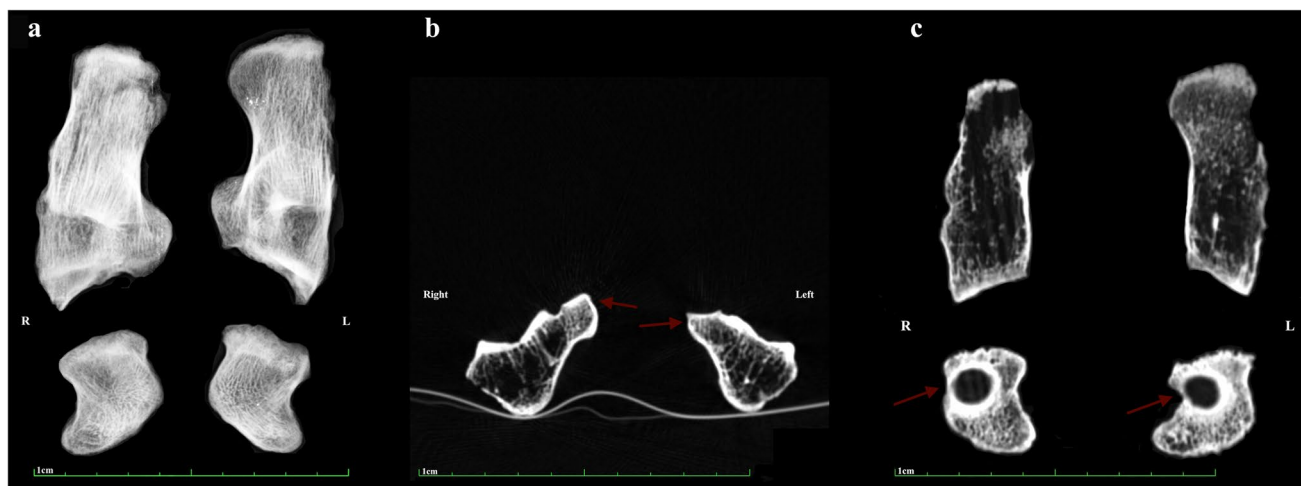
Antero-posterior X-ray image (a) of the calcanei and navicular bones, coronal CT scan (b) of the anterior talar facet (the arrows show the sustentaculum tali), and transverse CT scan (c) of the calcanei and navicular bones with circular lack of bone tissue (arrows)
